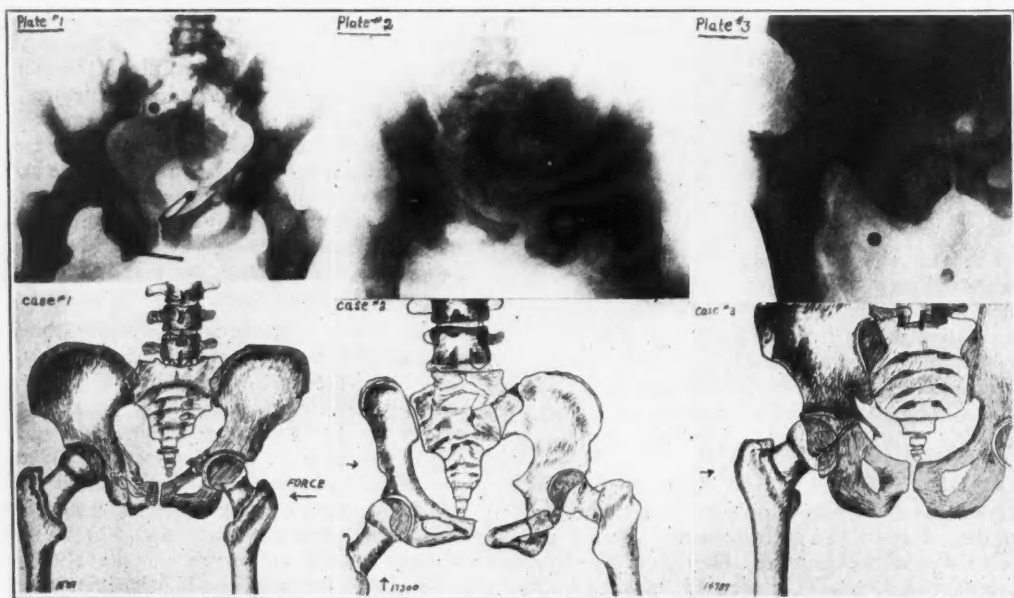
Shows common type of pelvic comminution. X-ray findings: fracture of pubic rami and ischiopubic region on right with moderate dislocation of fragments and little or no distortion of pelvic ring.
